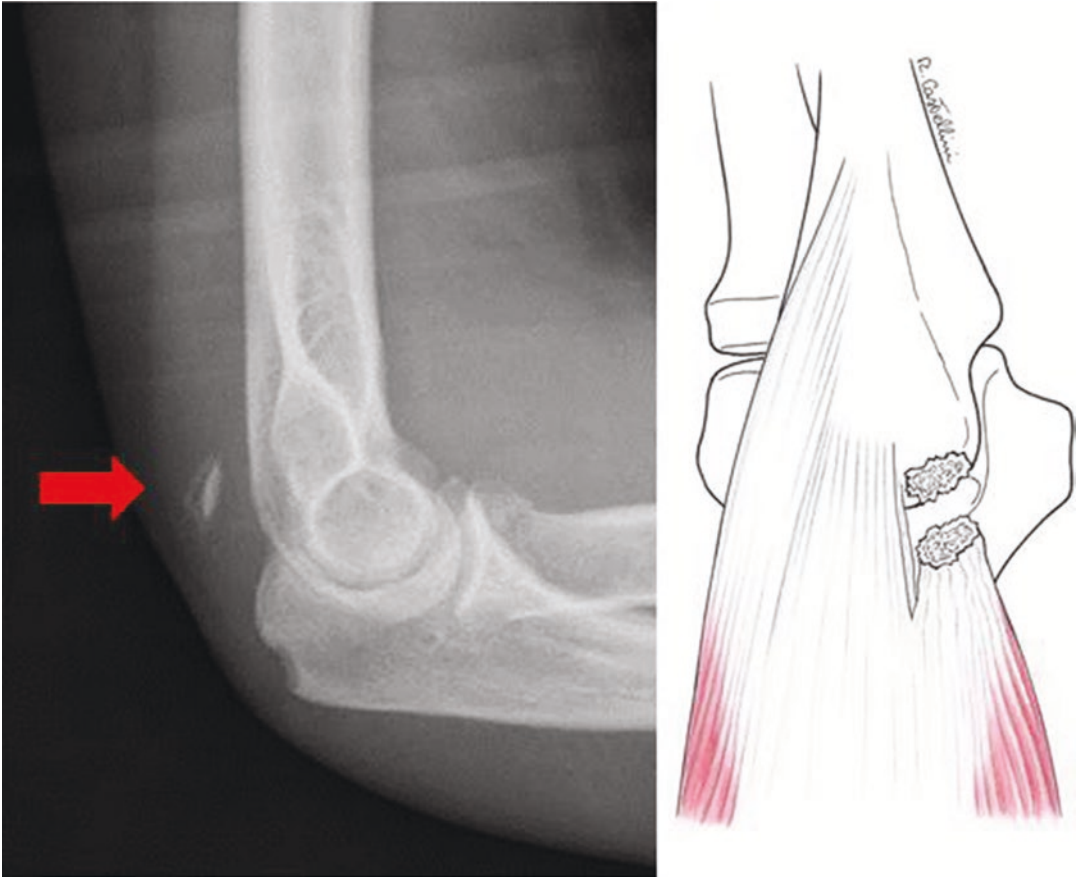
Lateral elbow X-rays are useful in confirming the diagnosis if a small extra-articular avulsion fracture of the olecranon (flake sign) is present
